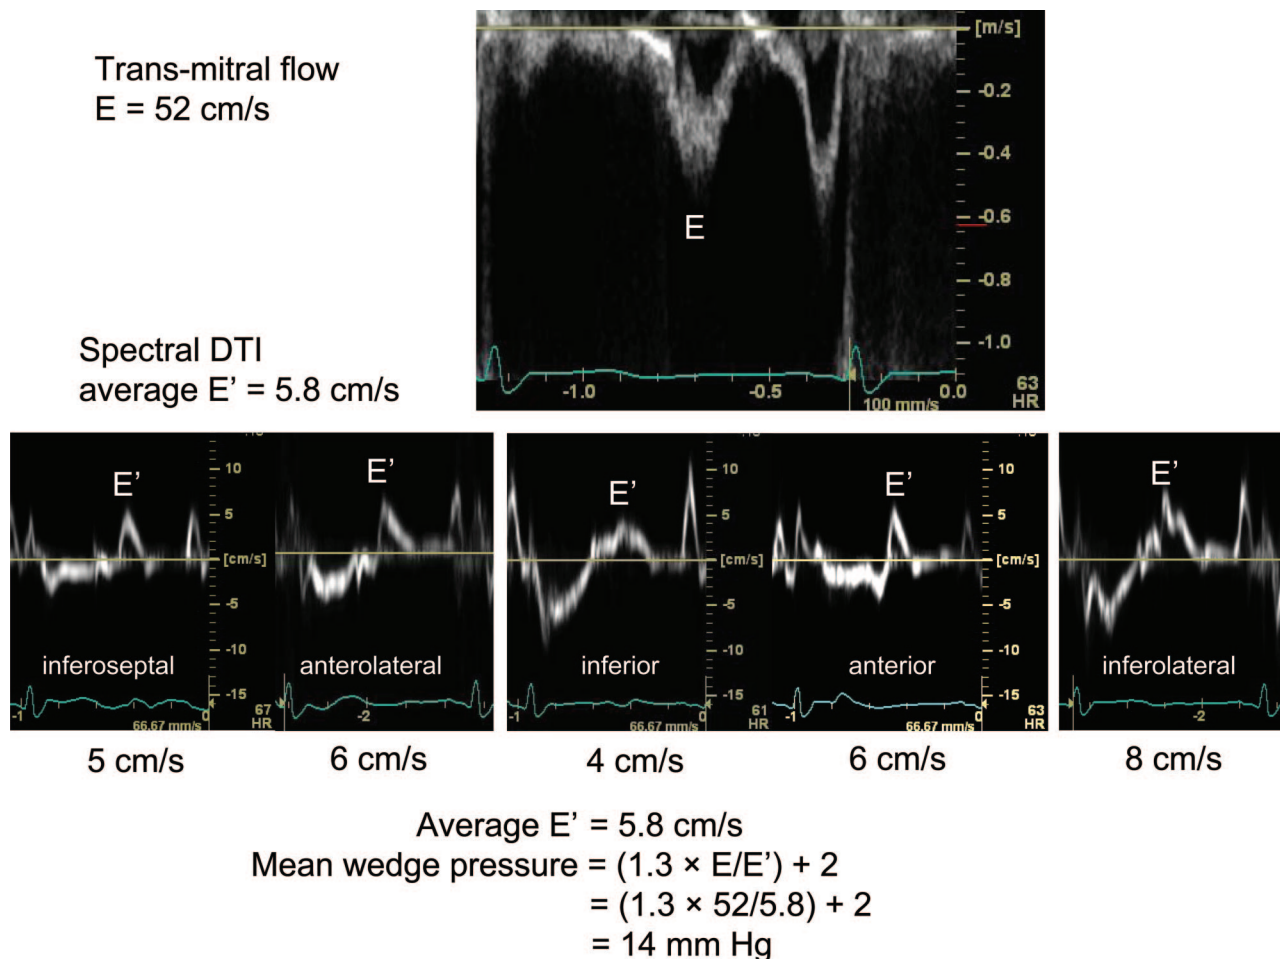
Estimation of filling pressures with Doppler tissue imaging (DTI). Mean capillary wedge pressure is calculated using the ratio of transmitral flow early velocity (E) and average early diastolic myocardial velocity (E'): mean wedge pressure = $(1.3 \times E/E') + 2$ mm Hg. Transmitral flow is recorded with pulsed wave Doppler at the tips of mitral valve leaflets, and spectral DTI velocities from basal myocardial segments, next to the mitral annulus. The antero-septal myocardial velocity was not recorded because of increased Doppler angle.
